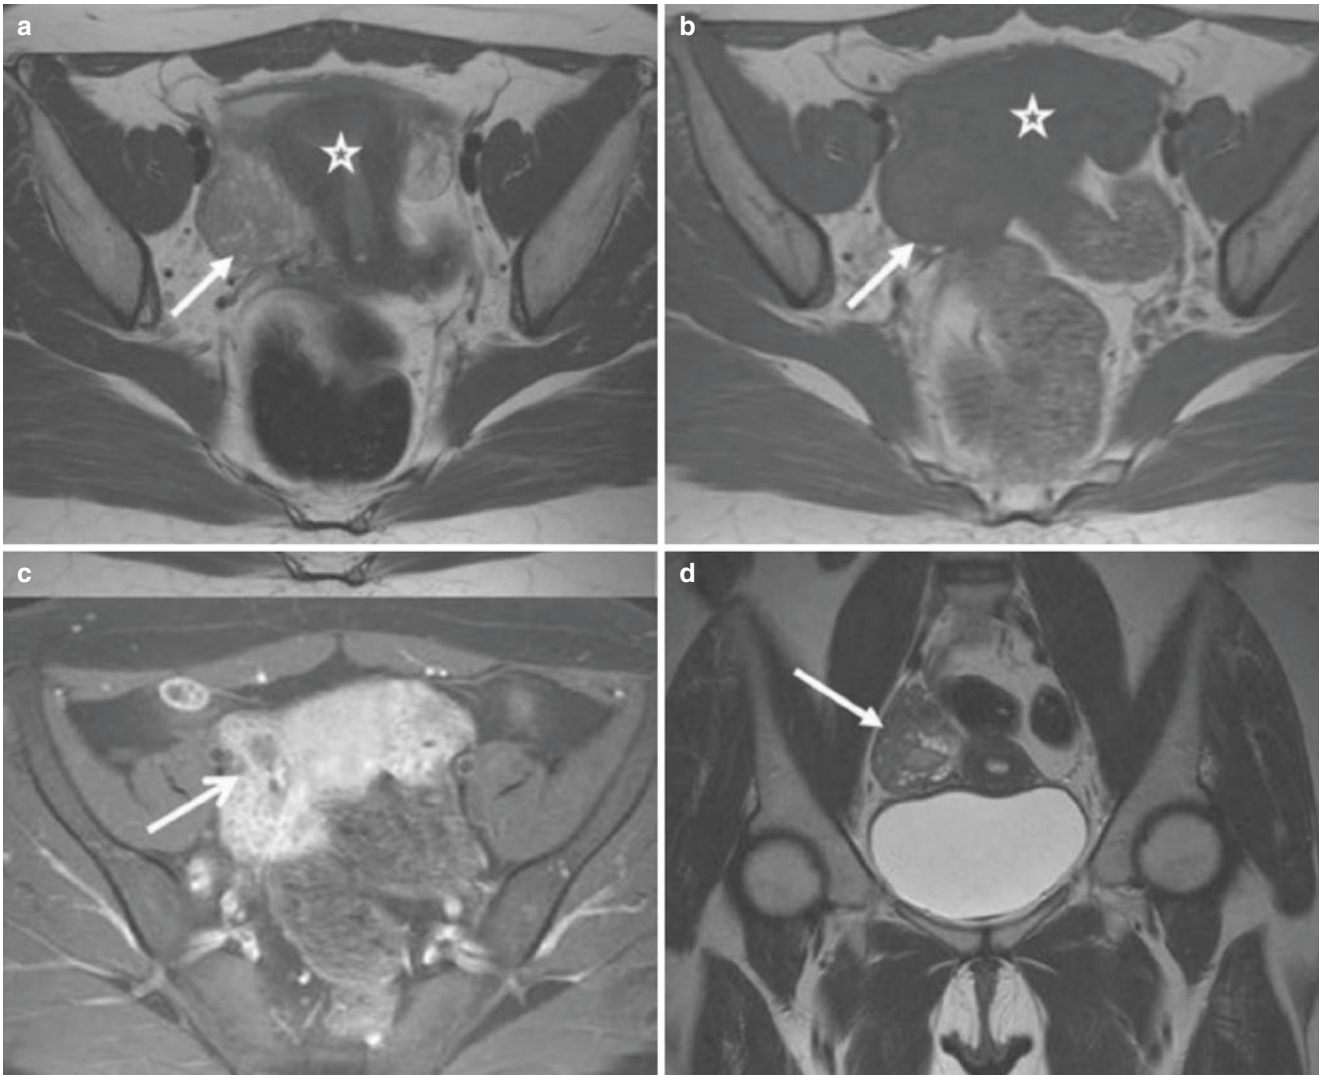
Salpingitis: MRI of the pelvis, showing the presence of serpiginous formation in the right adnexal region (*arrows a, b, d*), clearly separated from the uterus (*stars in a, b*), with intense parietal enhancement, by contrast, featuring its inflammatory nature (*arrow c*). The
